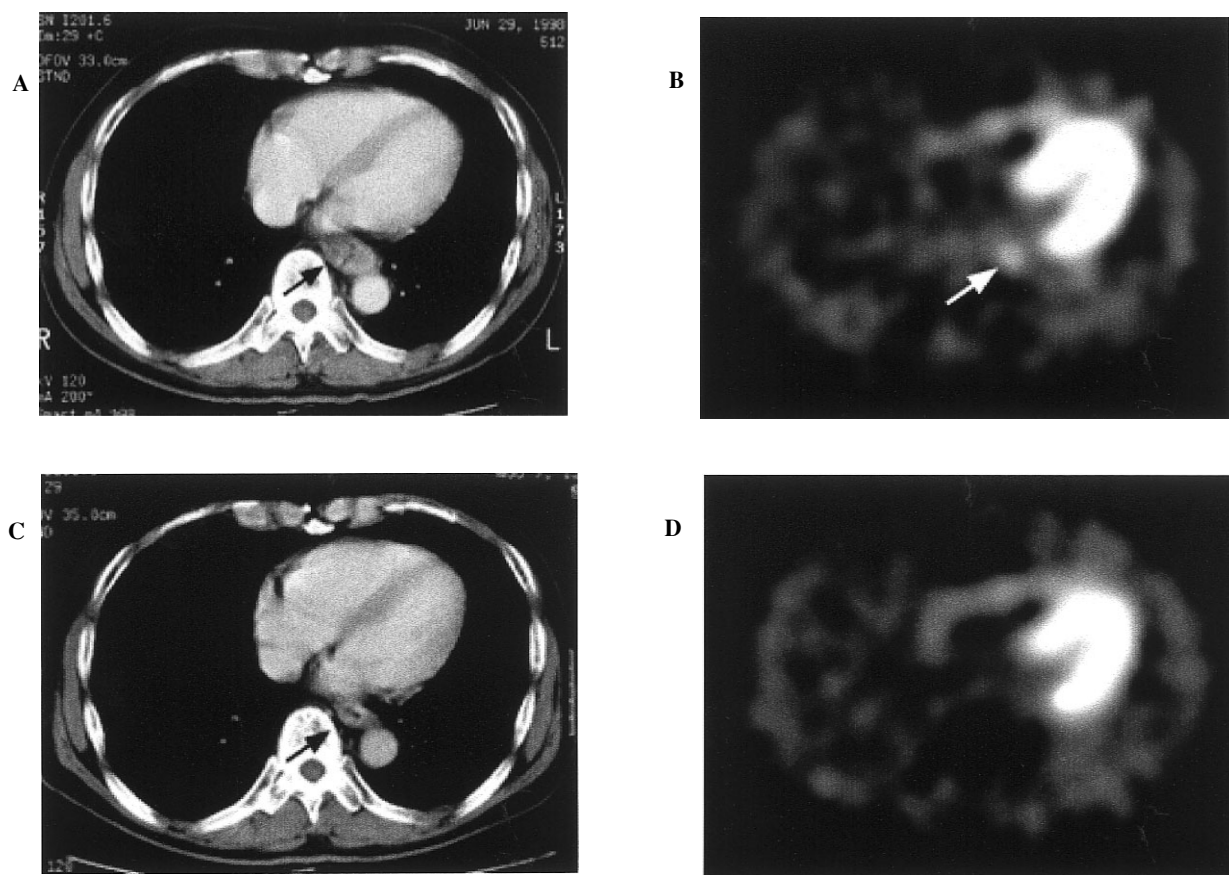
A 61-year-old man with poorly differentiated squamous cell carcinoma in the lower thoracic esophagus who had a pathologically complete response after chemoradiotherapy. A, Pre-chemoradiotherapy CT demonstrated a thickened esophageal wall, representing advanced esophageal carcinoma. B, Pre-chemoradiotherapy thallium-201 SPECT showed an area of increased accumulation near an area of physiological uptake by the heart, corresponding to the esophageal carcinoma identified on the CT images. C, Post-chemoradiotherapy CT demonstrated that the thickened wall revealed by contrast enhancement persisted despite a decrease in wall thickness. D, Post-chemoradiotherapy SPECT images did not reveal any focal accumulation in the esophagus.
